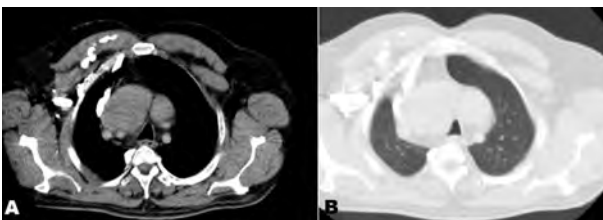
Mediastinal (A) and parenchymal (B) cross section computed tomography scans of vena cava superior compression
